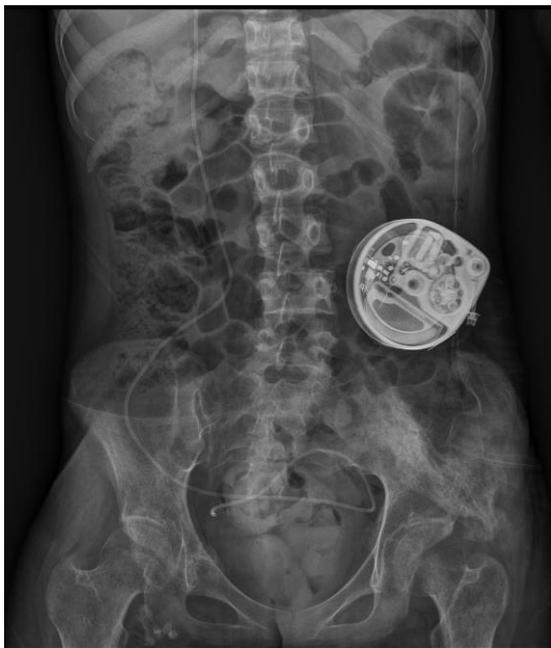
Simple Abdomen x-ray after intrathecal Baclofen pump insertion showed proper positioning of the device. A dose of 100ug/day of Baclofen was continuously injected.
